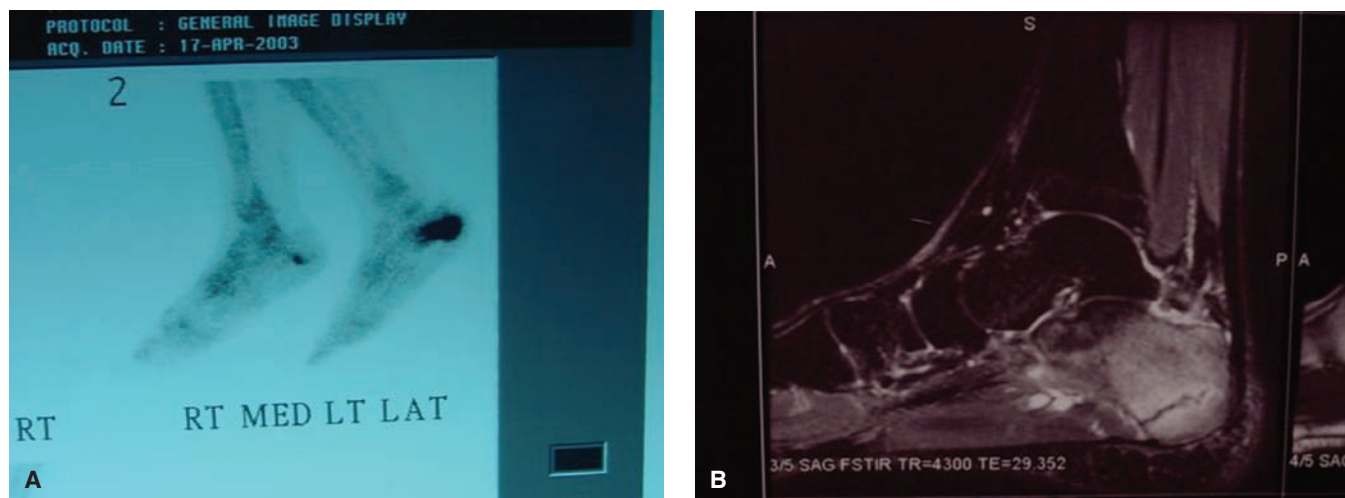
A: Bone scan for stress fracture. B: MRI for stress fracture.
